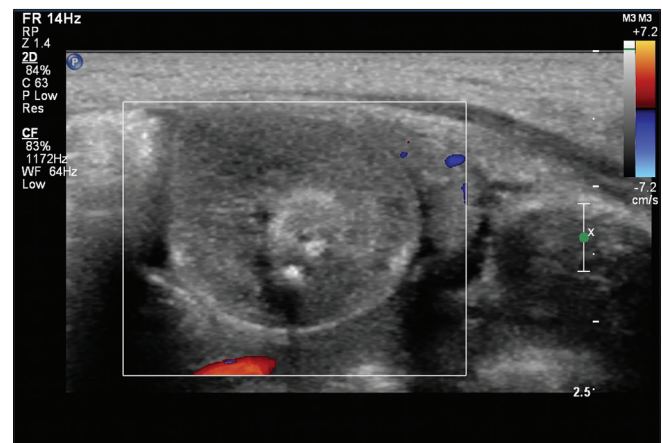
Postnatal USG shows cystic lesion with calcifications on left side of urinary bladder with no internal vascularity on Doppler study. These findings were similar on prenatal USG and diagnosis of cryptorchid testicular teratoma was assured
